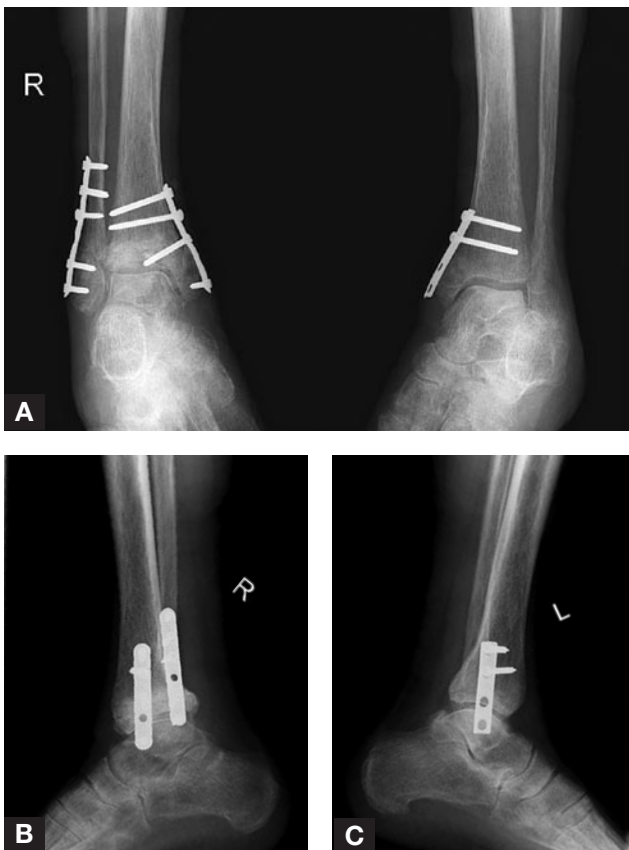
Preoperative (A) anteroposterior radiograph of left and right ankles, (B) lateral radiograph of right ankle, and (C) lateral radiograph of left ankle show bilateral medial malleoli fractures with fracture of lateral malleolus on right.
